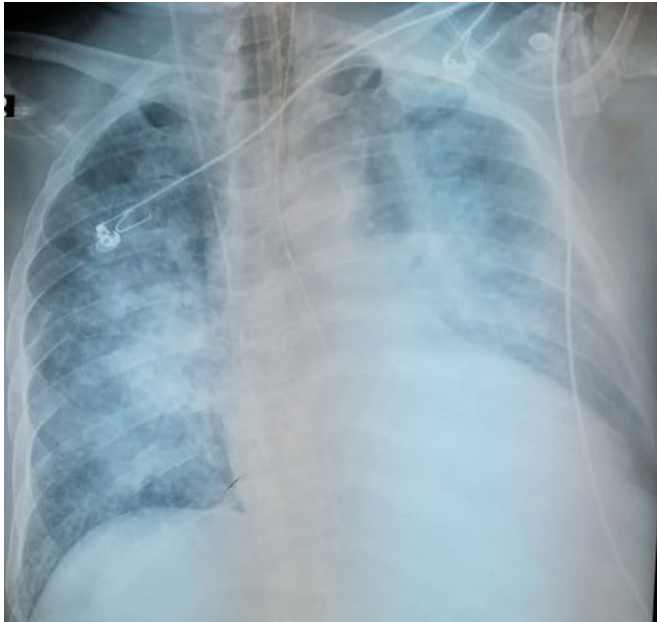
Chest X-Ray (CXR) showed bilateral infiltrates.
